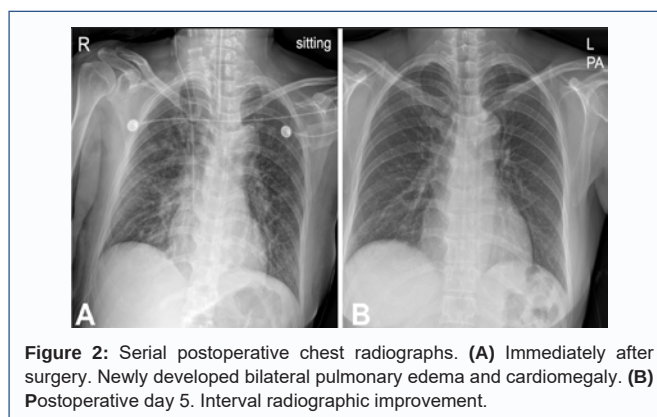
Serial postoperative chest radiographs. (A) Immediately after surgery. Newly developed bilateral pulmonary edema and cardiomegaly. (B) Postoperative day 5. Interval radiographic improvement.
